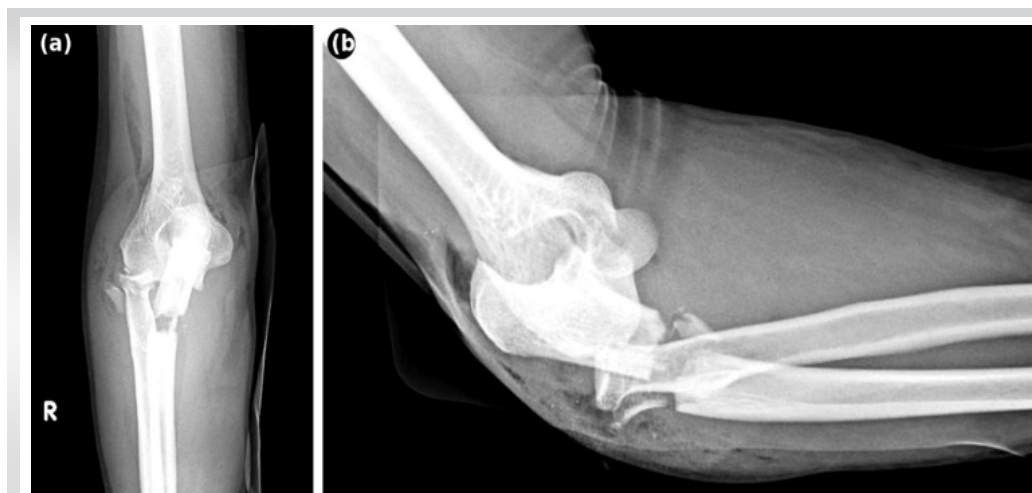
Pre-operative plain radiographs of the right elbow. (a) Anteroposterior view demonstrating proximal ulnar shaft fracture and disrupted elbow congruence. (b) Lateral view confirming posterior ulno-humeral dislocation.
